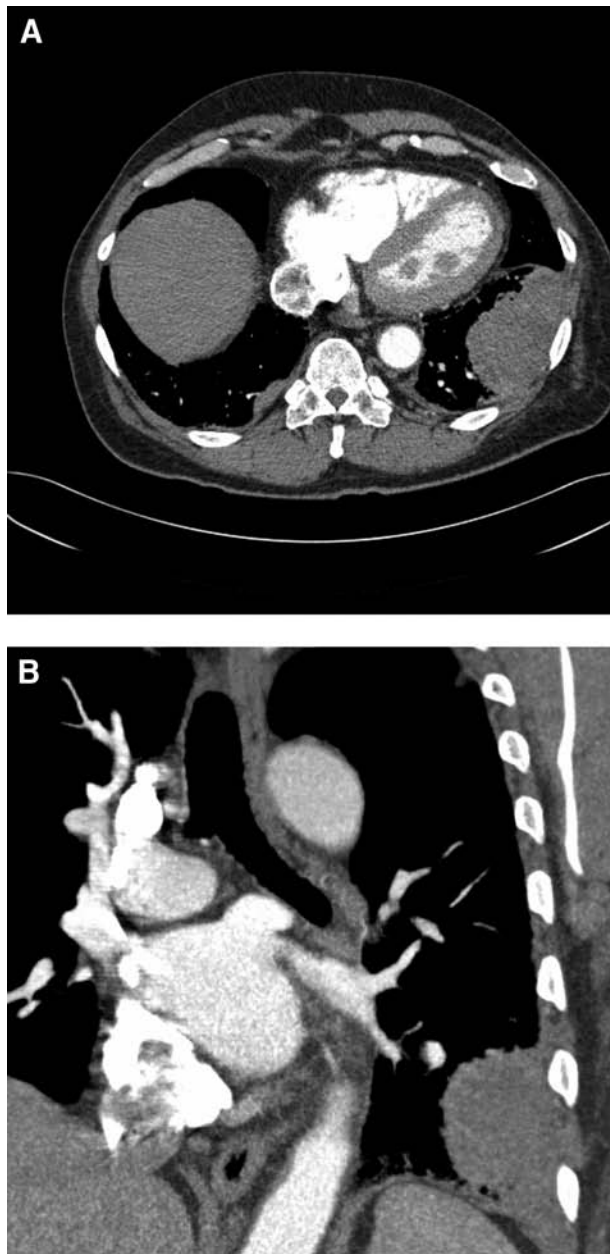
A, A computed tomography angiogram of the chest showing a large soft tissue mass within the inferior left hemithorax measuring approximately 3.2 × 1.6 in. B, A CT angiogram of the chest showing left apical pleural thickening and a very small left pleural effusion. Within the left lower lobe laterally is a soft tissue mass of 3.3 × 1.6 × 2.2 in. that abuts the pleural surface and demonstrates acute angles with the chest wall.
